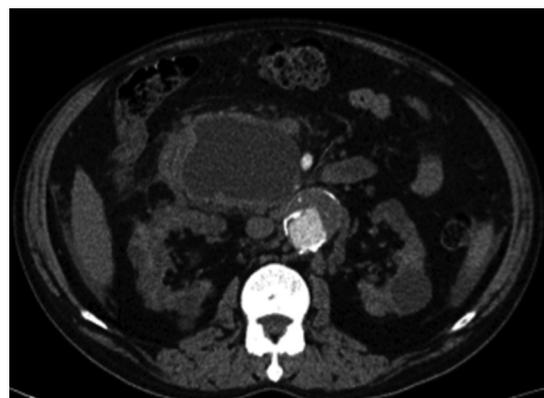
Pancreatic pseudocyst. Axial contrast enhanced CT image of abdomen shows a thick walled lowdensity nonenhancing cystic lesion in the midline.
